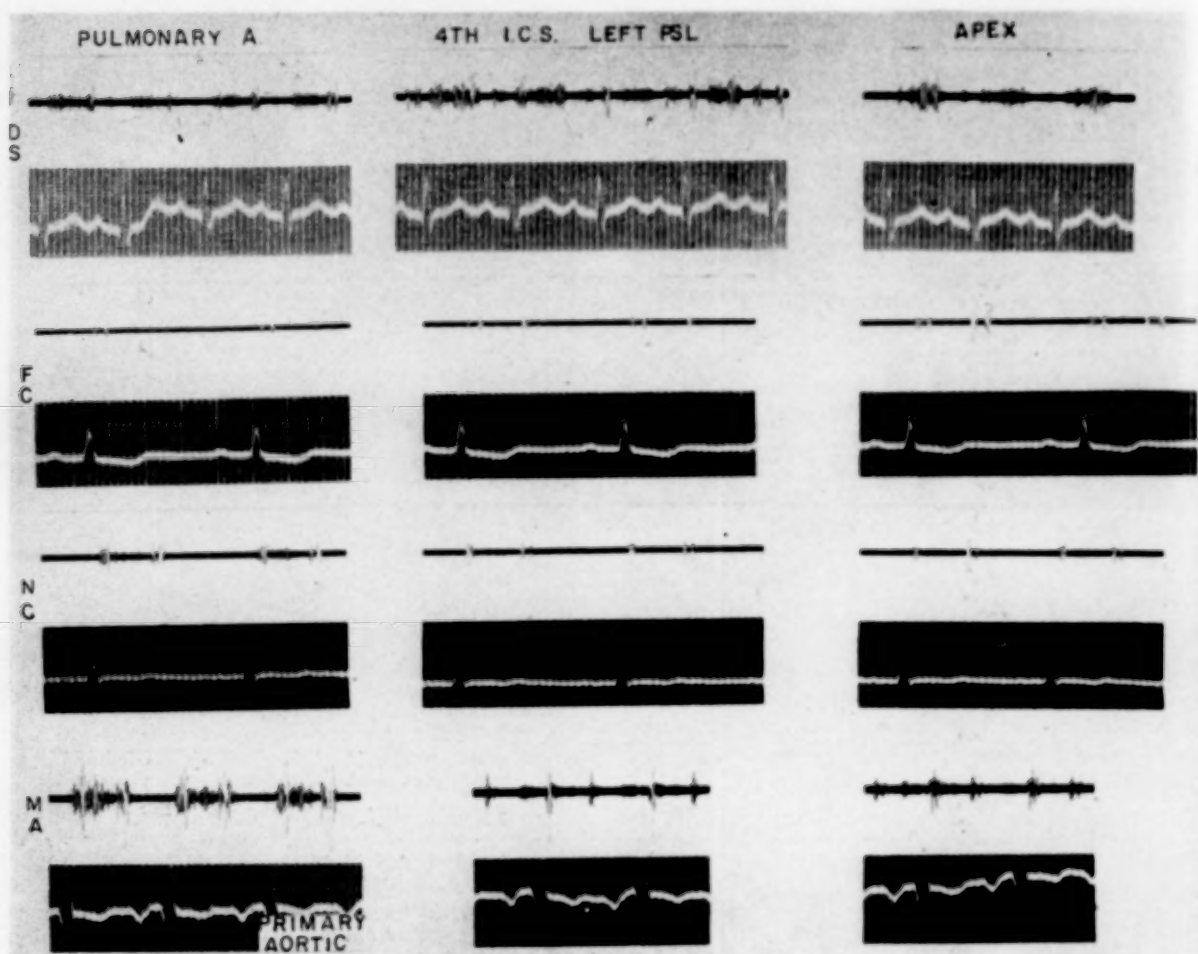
All records were taken with the Hindle model, Cambridge stethocardiograph at 50 mm./second. Comparison of intensity between patients is not possible since sensitivities were individually adjusted. Case I (D. S.). First sound of variable magnitude, but fairly loud at fourth intercostal space; very soft at apex and difficult to distinguish from the systolic murmur that follows. Second sound is not accentuated over the pulmonary area but is inconstantly split. A loud holo- or late systolic murmur is recorded at the fourth left intercostal space. An early systolic murmur is recorded at the pulmonary area. A holosystolic murmur of greater intensity and different configuration is recorded at the apex. A late diastolic murmur beginning with auricular contraction is recorded at the apex and with more intensity at the left sternal border. It is not crescendo in configuration and is not followed by an accentuated first sound. This murmur is also recorded faintly in the pulmonary area. Case II (F. C.). First sound appears to be widely split with the second element recorded over the entire precordium. In view of its intensity over the pulmonary artery and the presence of the very severe pulmonary hypertension, this is probably an early systolic ejection sound of the pulmonary artery [39]. A faint early systolic murmur is seen over the pulmonary artery. A holosystolic murmur is recorded at the apex, but well transmitted to the left parasternal line. First sound at the apex is soft and of considerably less intensity than the second sound in this area. A third heart sound is recorded at the apex and transmitted to other areas. In the pulmonary area, the second element of the second sound is surrounded by a few vibrations possibly indicating a faint murmur of pulmonary insufficiency (not heard). Case III (N. C.). First sound is soft and single, particularly at the apex. Second sound is widely split with the accentuation of the second element. A systolic murmur of moderate intensity is recorded maximally at the pulmonary area; a fainter systolic murmur thought to represent a second murmur is seen at the apex. Case IV (M. A.). First heart sound is accentuated at the left sternal border, but is considerably softer at the apex. It is, however, of greater intensity than the second sound in this area. The second sound is fairly loud, somewhat accentuated and moderately split at the base (primary aortic area). In the latter area, an early systolic murmur of considerable intensity is recorded. This murmur was heard with greater intensity, at the pulmonary area, but records were unsatisfactory. A second systolic murmur of much less intensity is recorded at the apex. A loud presystolic murmur is recorded with somewhat more intensity at the sternal border than at the apex.
